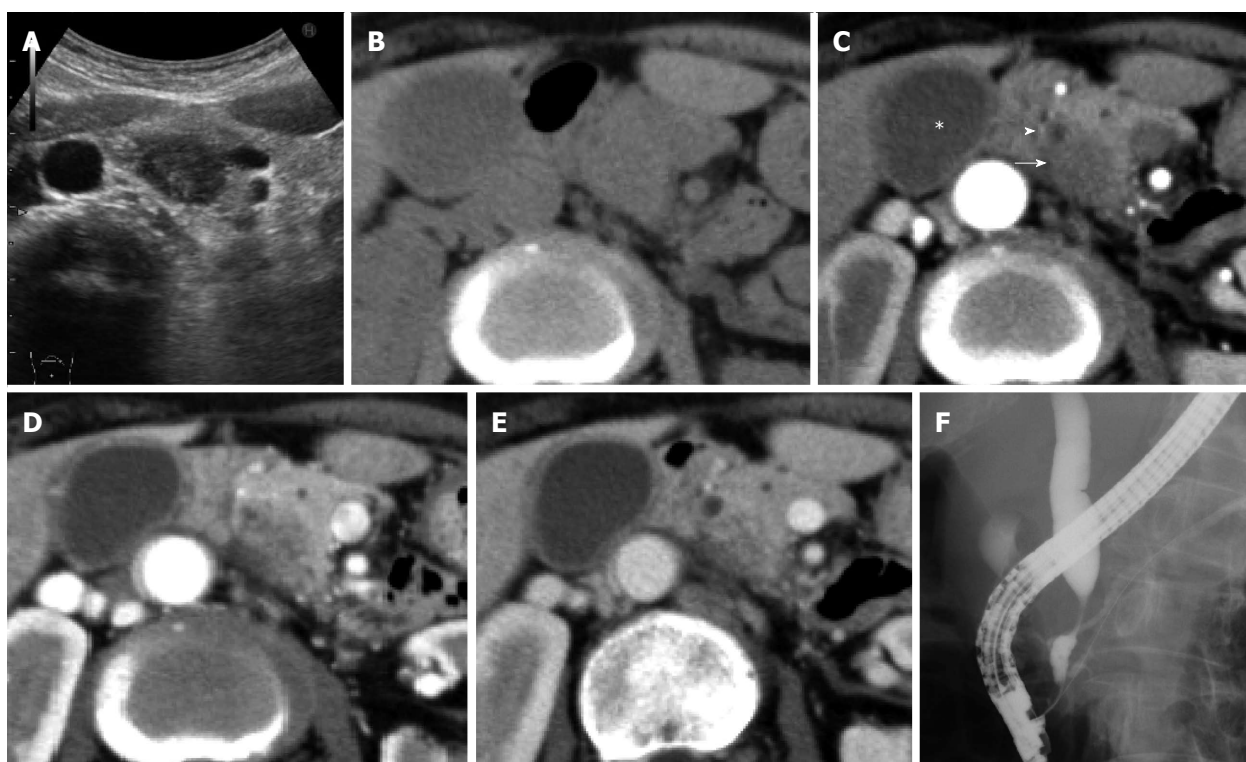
Preoperative images. A: An ultrasonogram showing a slightly ill-defined hypoechoic mass at the pancreatic head; B-E Abdominal CT scans: The pancreatic mass is slightly hypodense on simple CT; C: Enhanced CT shows a non-enhancing mass (arrow) located adjacent to the bile duct (arrowhead) at the arterial phase. Note that the walls of the gallbladder (asterisk) and bile duct are thickened; D and E: The mass has sporadic enhancement at the later phase; F: A Cholangiogram showing a tapered distal biliary stricture consistent with extrinsic compression by the pancreatic mass. CT: Computed tomography.
